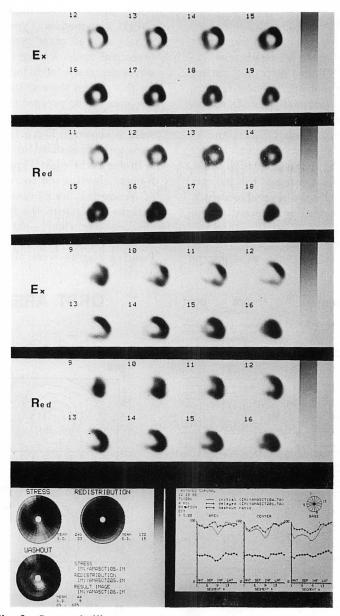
Stress thallium scan (SPECT) of the patients in Fig. 2.
